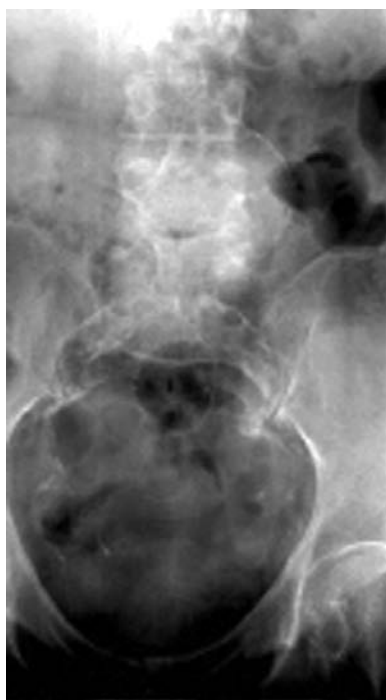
Radiograph shows calcification of the abdominal aorta. The left wall is clearly depicted and appears aneurysmal; however, the right wall overlies the spine
